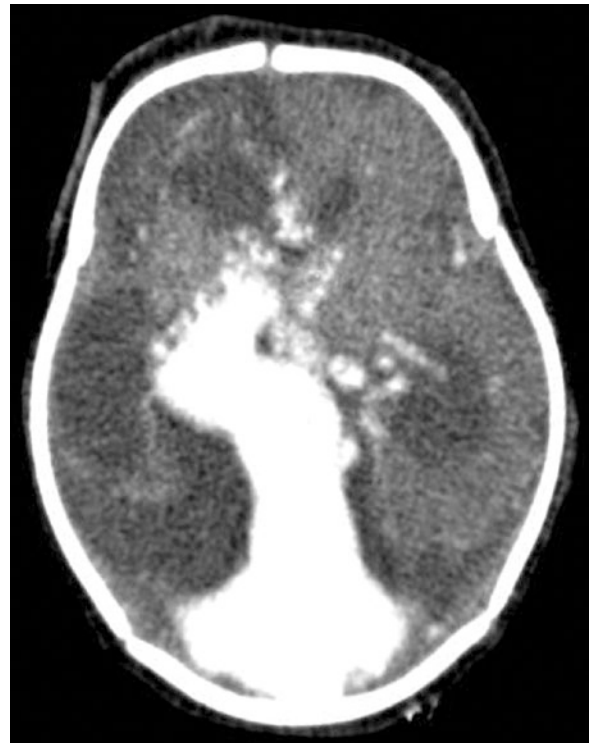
VGAM. Axial contrast-enhanced CT image shows a large, enhancing, tortuous VGAM. Multiple arterial feeders are identified. There is hydrocephalus and parenchymal infarction within the right cerebral hemisphere
